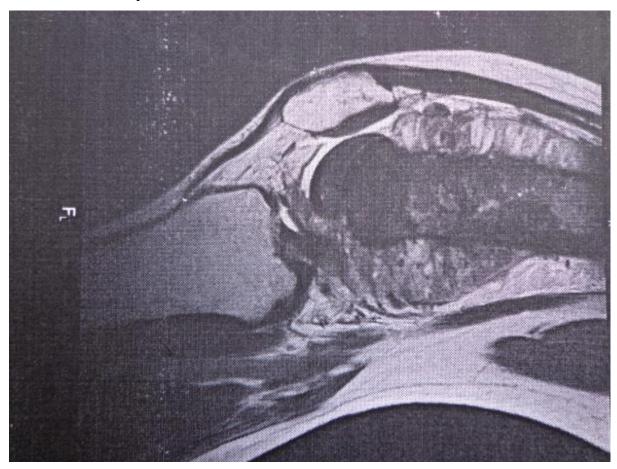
MRI of the left knee joint of patient N. Pronounced cancerous periostitis, destruction of the distal end of the femur, multiple spicules.
